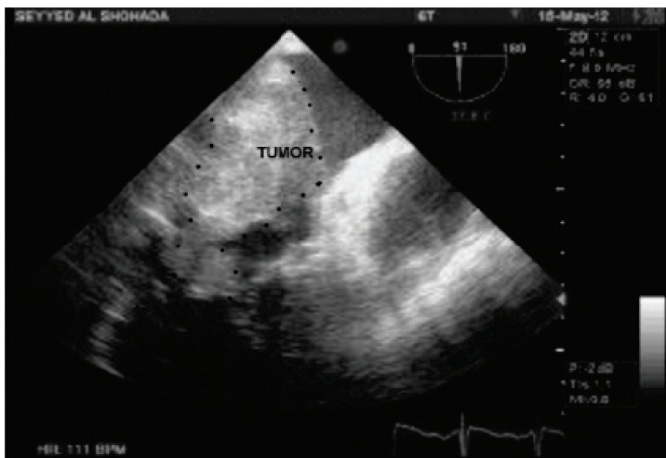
echocardiographic view of large left atrium tumor
